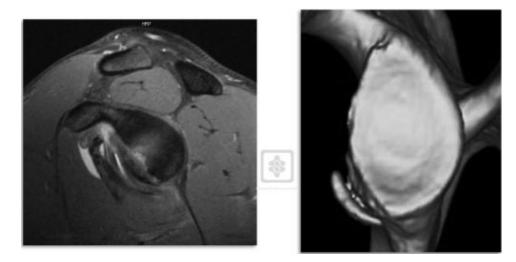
Bone loss. MRI arthrogram and CT demonstrating anterior glenoid bone loss commonly encountered in collision atheletes.
